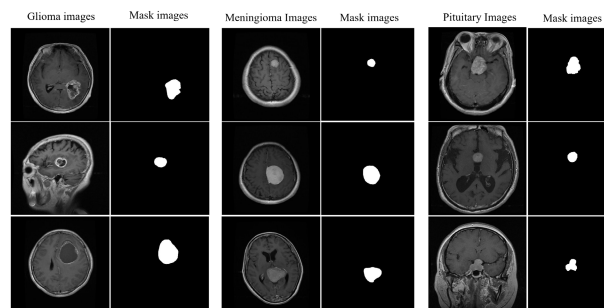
Multi-class BT T1-weighted CE-MRI sample dataset.
